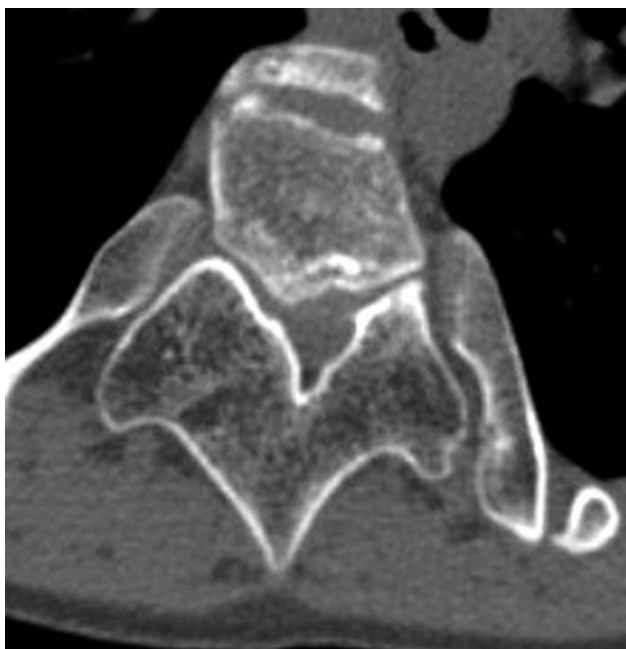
Hypertrophy of posterior arch of T5 vertebra on axial CT scan.
